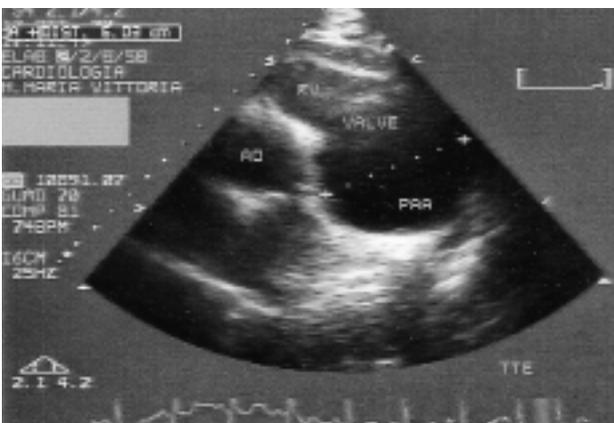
Transthoracic echocardiography (TTE): a pulmonary artery aneurysm (PAA), approximately 6 cm in diameter; is shown in the parasternal short-axis view at the level of the aorta (AO) and main pulmonary trunk (left panel) and in the subcostal short-axis view of the right ventricular outflow tract (right panel). PA = pulmonary artery; RV = right ventricle.
